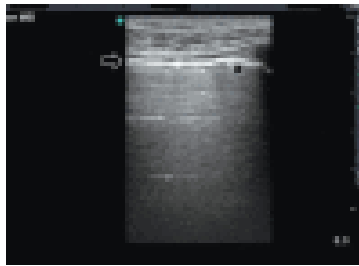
Ultrasound image, transthoracic showing
